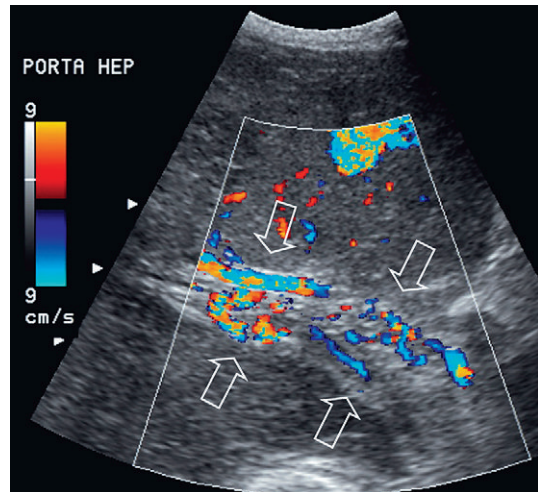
Oblique colour Doppler image of the porta hepatis. A normal portal vein could not be visualised. Instead there is a plexus of small vessels with hepatopetal flow (arrows). After portal vein thrombosis this web of small vessels reconstitutes portal flow to the liver and is known as cavernous transformation of the portal vein.
